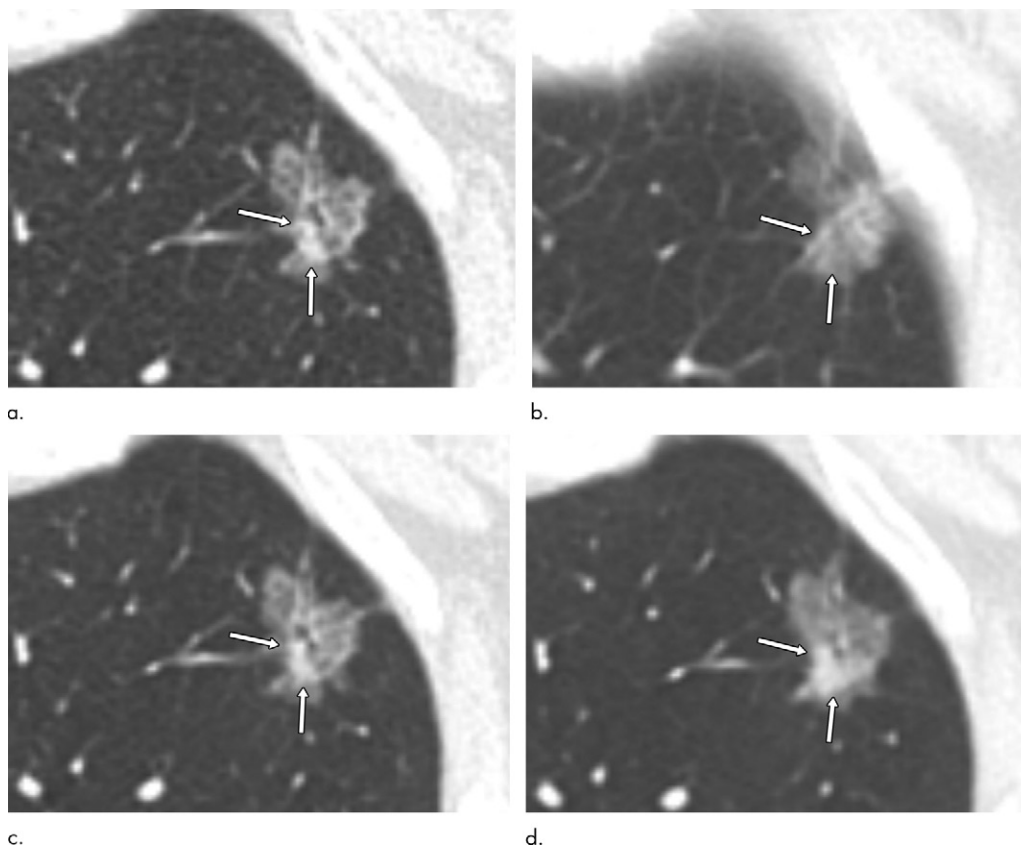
Images in a 72-year-old woman with pathologically proven invasive adenocarcinoma in left upper lobe of lung. Axial contrast-enhanced CT scans obtained with (a) 1-mm-thick sections, (b) 5-mm-thick sections and images converted from original (c) 3-mm, and (d) 5-mm-thick sections after application of a super-resolution algorithm show a 16-mm well-defined part-solid nodule with a 5-mm solid portion in the left upper lobe. The solid portion of the nodule (arrows) is well defined on the 1-mm image (a) and not clearly delineated on the 5-mm image (b). The computer-aided detection (CAD) algorithm depicted the nodule on 1- and 3-mm images but missed it on the 5-mm image. After application of the super-resolution algorithm (c, d), the solid portion was retrieved, and CAD detected the nodule on both super-resolution 3- and 5-mm images.
